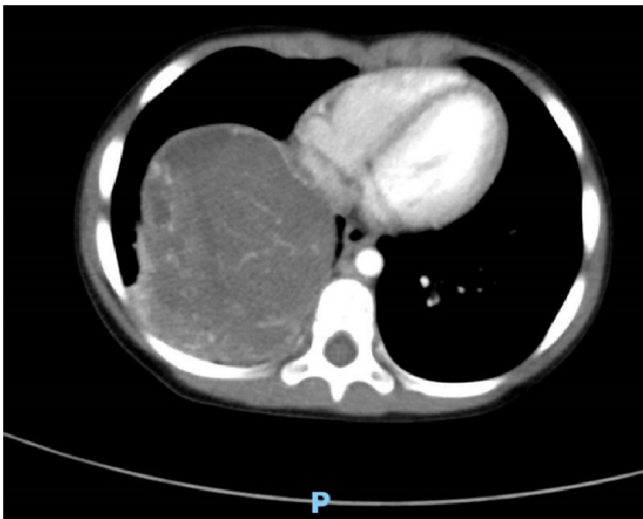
Chest CT enhancement shows uneven and obvious enhancement of the lower right thoracic mass.
